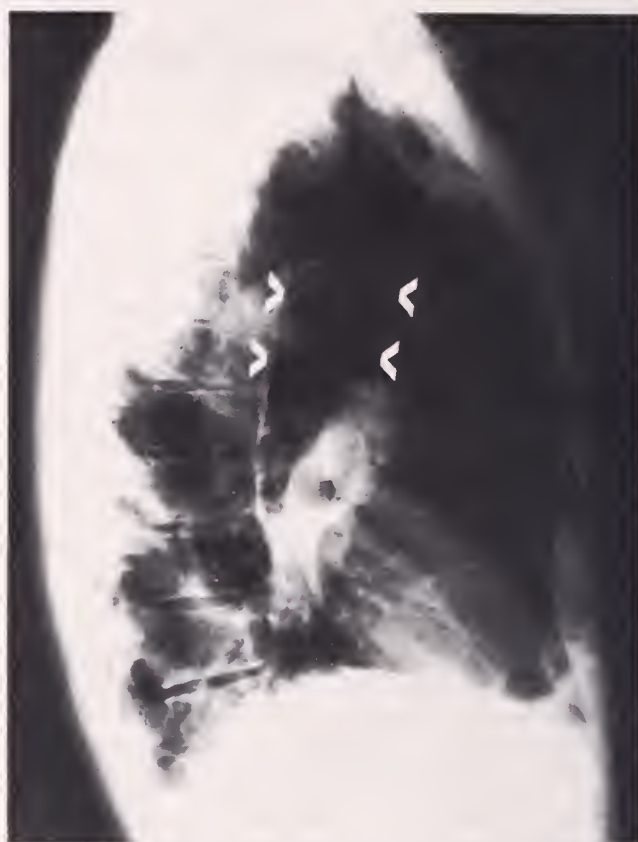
Lateral chest roentgenogram showing wide tracheal air column.
